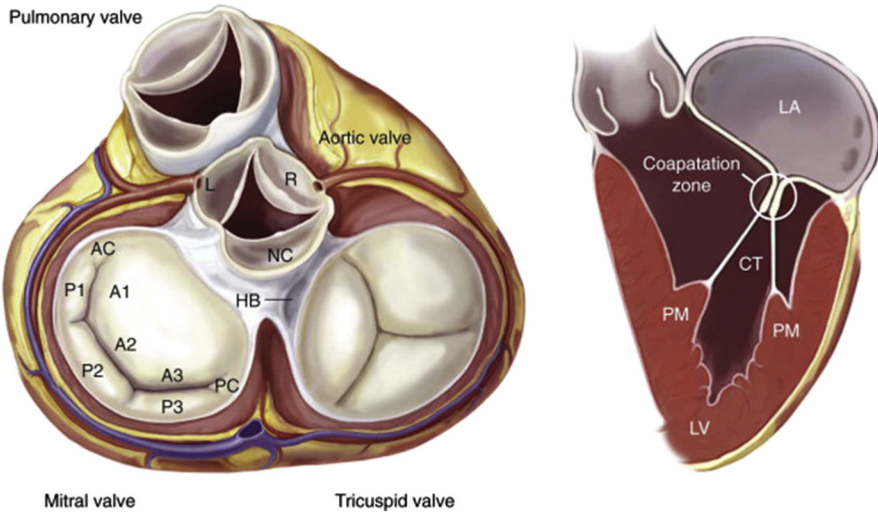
Anatomy of the mitral valve and mitral apparatus. (Left) Anatomic view of the cardiac valves in systole with the left and right atrium cropped away and the great vessels transected. The mitral valve apparatus consists of the mitral leaflets, mitral annulus, chordae tendineae, the papillary muscles, and the left ventricle. (Right) Normal function of the mitral apparatus brings both leaflets together in systole and creates the coaptation zone. A1, A2, A3, segments of the anterior leaflet; AC, anterior commissure; CT, chordae tendineae; HB, His bundle; L, left coronary cusp; LA, left atrium; LV, left ventricle; NC, noncoronary cusp; P1, P2, P3, segments of the posterior leaflet; PC, posterior commissure; PM, papillary muscle; R, right coronary cusp. (From Castillo JG, Adams DH. Mitral valve repair and replacement. In: Otto C, editor. Valvular heart disease: a companion to Braunwald's heart disease. 4th edition. Philadelphia: Elsevier Saunders; 2014. p. 327; with permission.)
